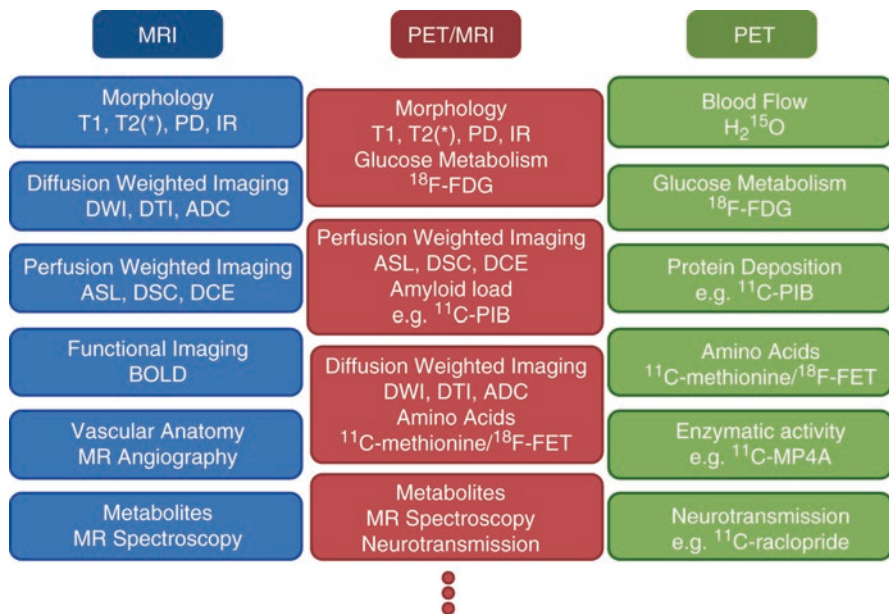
Some examples of the imaging potential of hybrid PET/MRI
